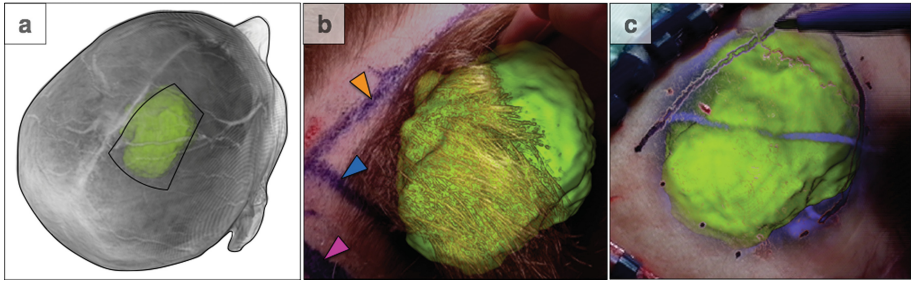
Case 2: (a) 3D rendered MRI and segmented tumour virtual patient model, showing position of patient head and location of the planned craniotomy. (b) The surgeon uses AR to determine the location and extent of the tumour. The blue arrow indicates the posterior boundary of a bounding box around the tumour and the pink arrow indicates the planned posterior boundary of the craniotomy that will allow resection of the tumour. The orange arrow shows the medial extent of the bounding box around the tumour, which is also the planned craniotomy margin. (c) The surgeon uses the AR view to trace around the tumour (see the felt marker in the top right of the image) in order to determine the size of the bone flap. Note the vessel (in purple) that was visualized in the AR view and was taken into account for the craniotomy. (Color figure online)
